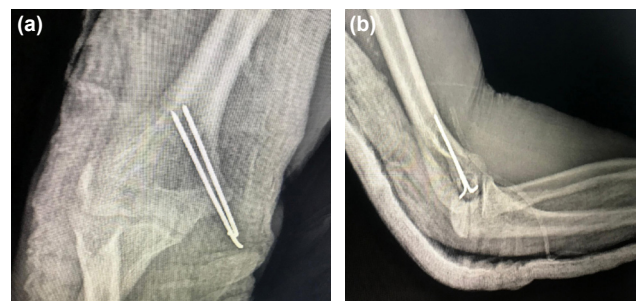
Post-operative anteroposterior (a) and lateral (b) radiographs show the anatomic reduction of the fracture with parallel 2 K-wires.
